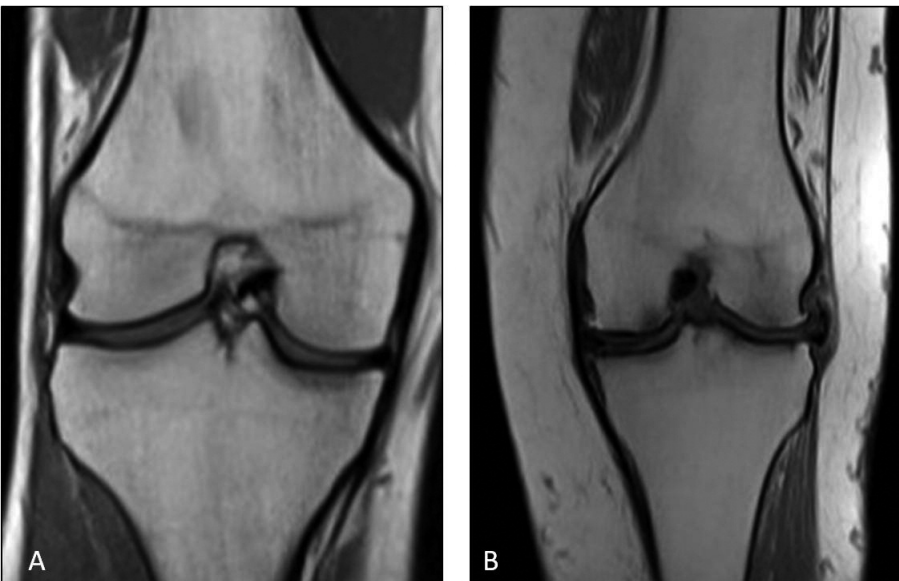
MRI (magnetic resonance imaging) coronal view in left normal and osteoarthritic knees from two different adult patients. A. Left normal Knee. B. Left osteoarthritic knee, in which the MRI signal intensity of the menisci is altered, the articular cartilage and the subchondral bone are altered with increased bone density.
